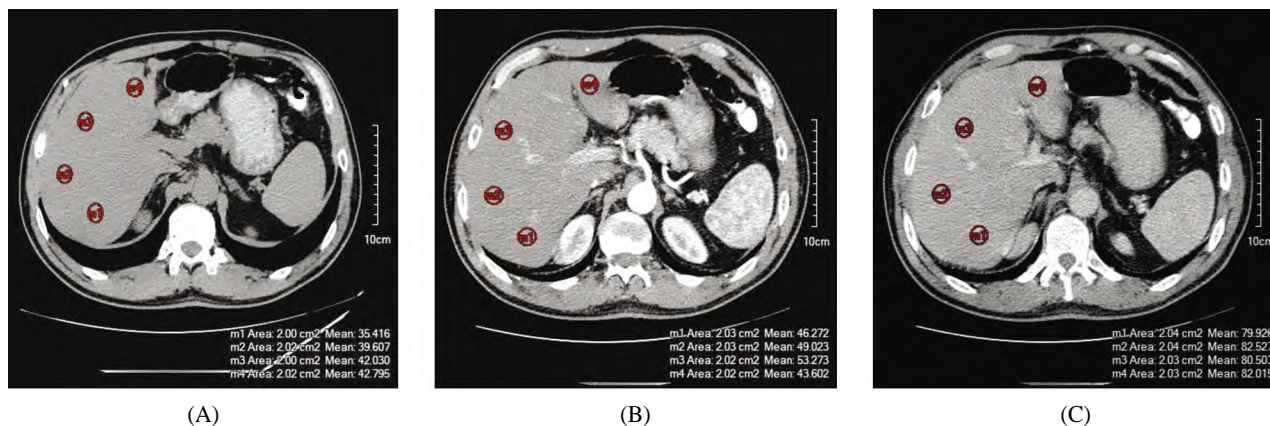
Triphasic CT of the liver in normal volunteer aged 45 years old. (A) Pre-contrast. (B) Arterial phase. (C) Porto-venous phase. A circular region of interest (ROI) with an area of approximately 200mm² was placed on the right posterior, right anterior, left medial, and left lateral liver segments on the slice with the largest liver parenchyma, avoiding the large vessels. The ROI was placed on a similar area and location in the different phases. The calculated CEF=0.74.
